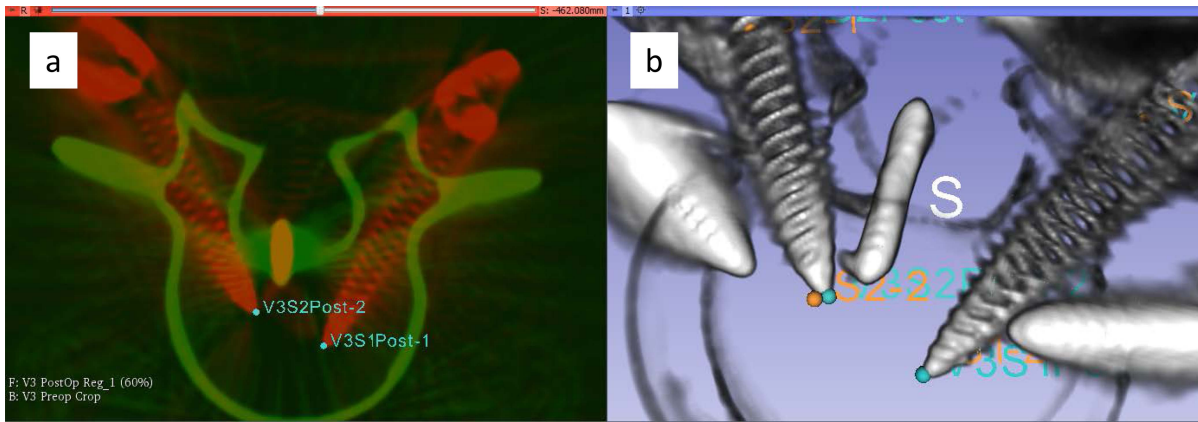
(a) C-arm CT image of synthetic vertebra after robotic screw placement (red) registered with preoperative image (green) showing identification of destination points (cyan). (b) Volumetric rendering of postoperative C-arm CT image showing both the identified preoperative planned (orange) and postoperative measured (cyan) screw destination locations.
